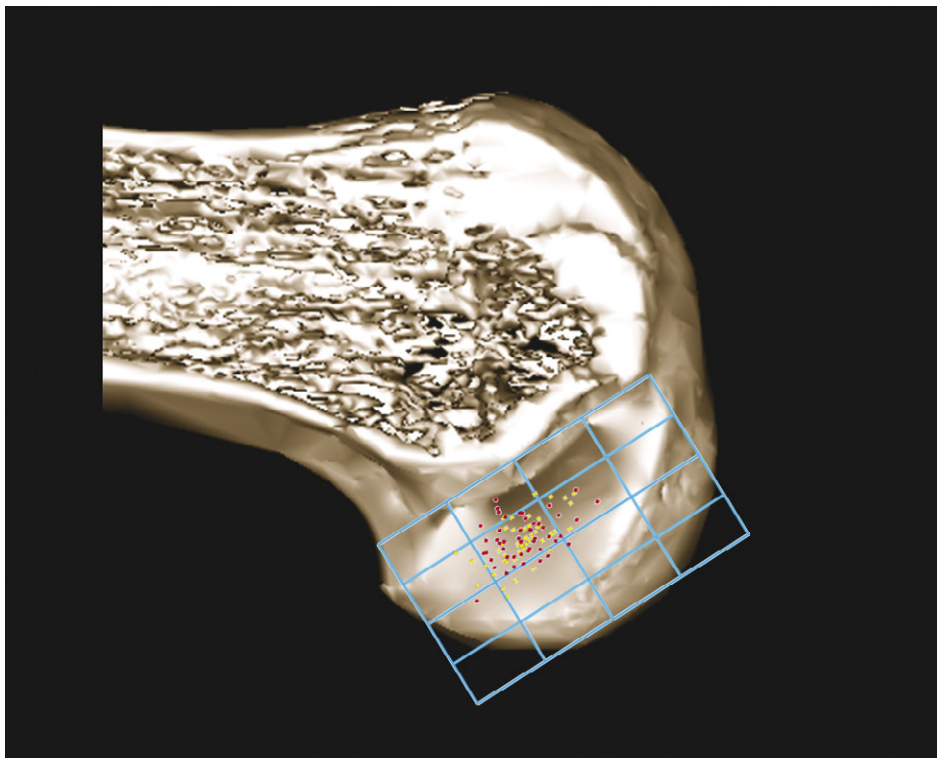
CAS (red dots) versus conventional (yellow squares) femoral tunnel intra-articular aperture position. They are displayed for clarification on a knee CT image of a randomly chosen image of a lateral condyle viewed from the medial side, with the quadrant overlay projected.
